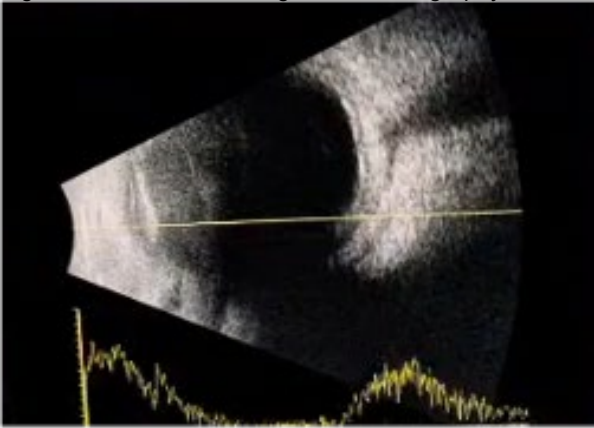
T sign on ultrasonography.
